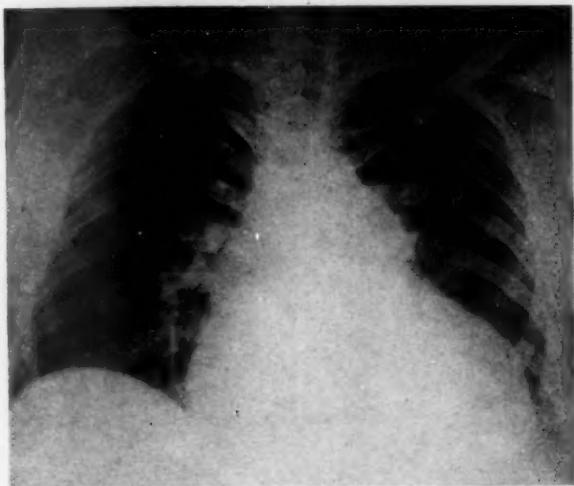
Roentgenogram made twelve days before death, showing marked enlargement of the heart. The heart measures 18.3 cm.; the thorax, 30.0 cm.
